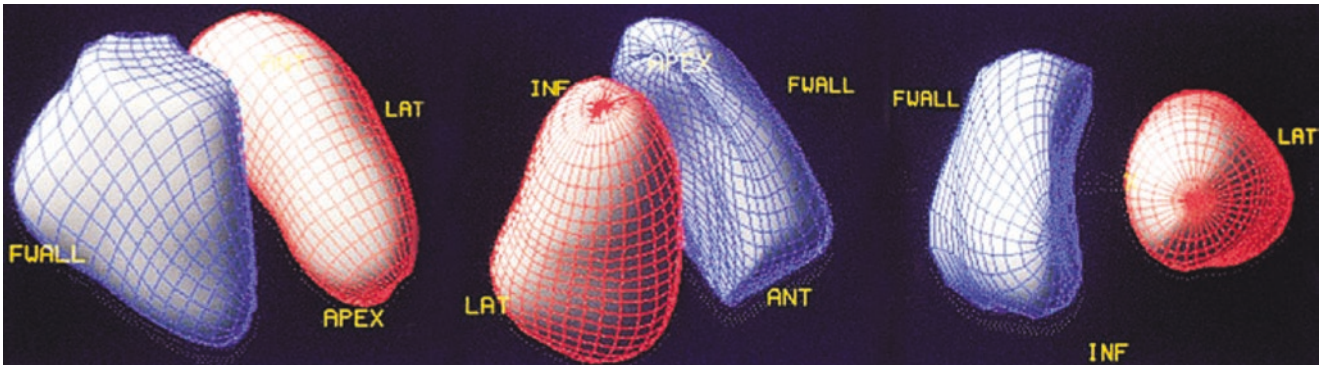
Gated blood pool single-photon emission CT (SPECT): left and right ventricle. ANT anterior LV wall, FWALL free RV wall, INF inferior LV wall, LAT lateral LV wall
